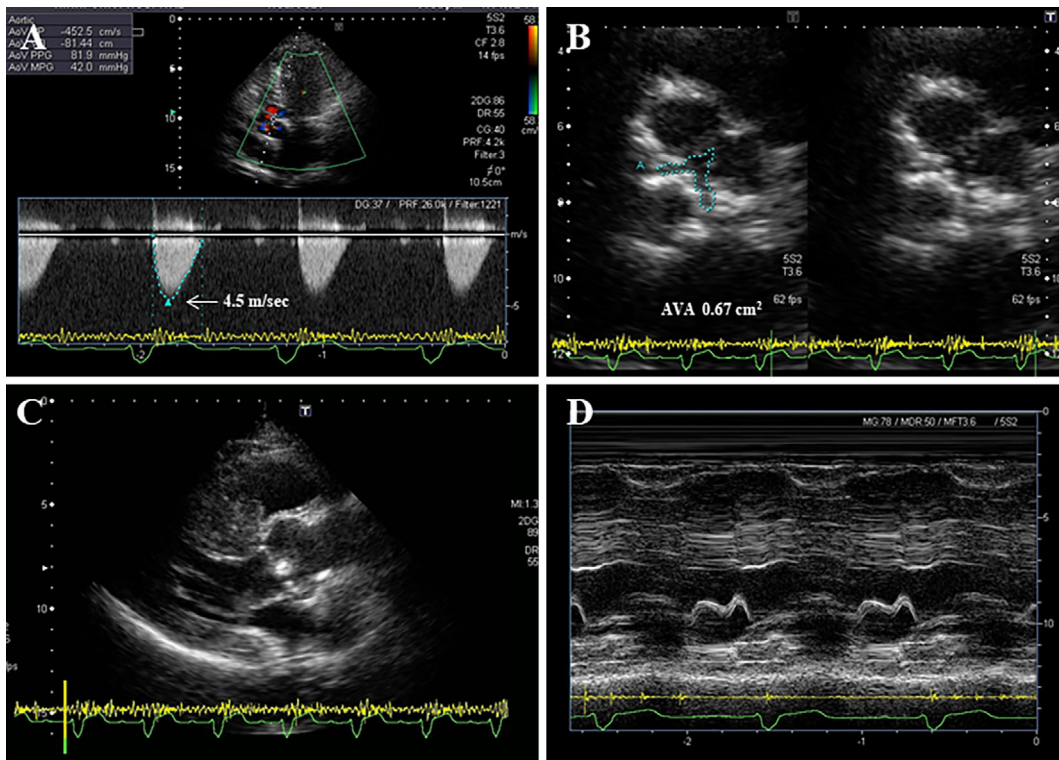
Standard transthoracic echocardiography. Continuous-wave Doppler measurement of peak aortic transvalvular velocity (A), aortic valve area (AVA) by planimetry (B), parasternal long-axis view (C), and M-mode recording at the mitral valve level (D).
